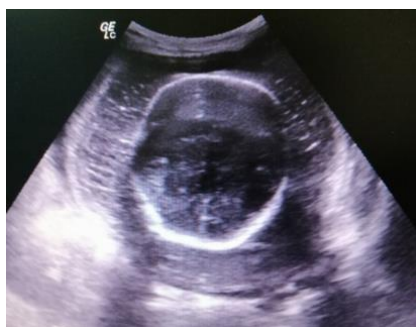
Obstetrical ultrasonography indicates fetal scalp oedema at 24 weeks POA
